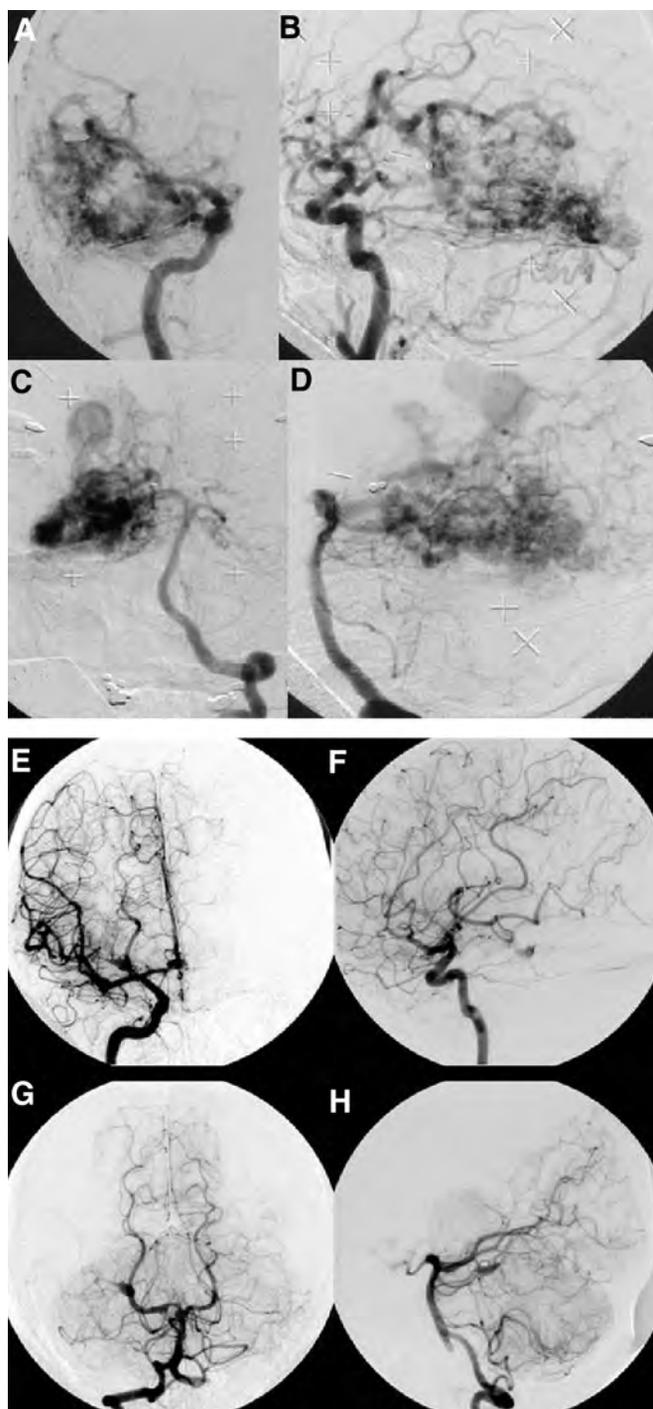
Large-volume AVMs defined by MRI and angiography (left) can be obliterated by performing staged radiosurgery (right).
